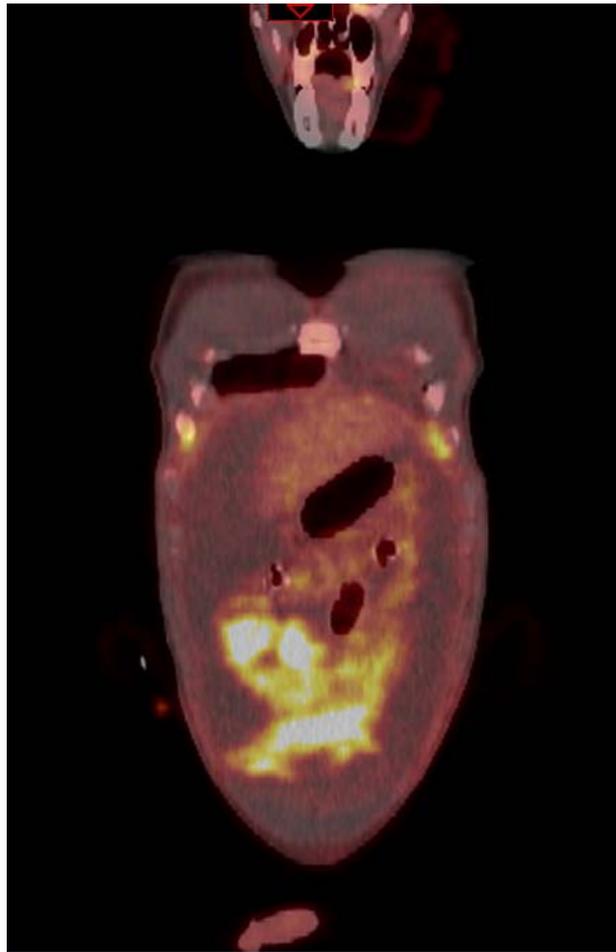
Positron emission tomography–computed tomography showing diffuse hypermetabolic activity within the omentum and peritoneal lining with large volume ascites.
